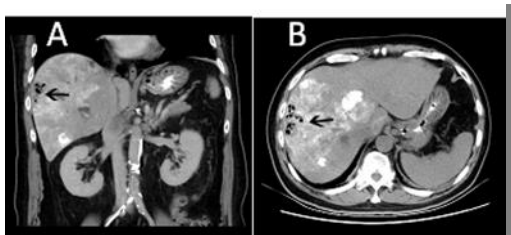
Post-embolization emergency CT scan showed irregularly liver nodules and tumors. In the right lobe, there were gas density.
